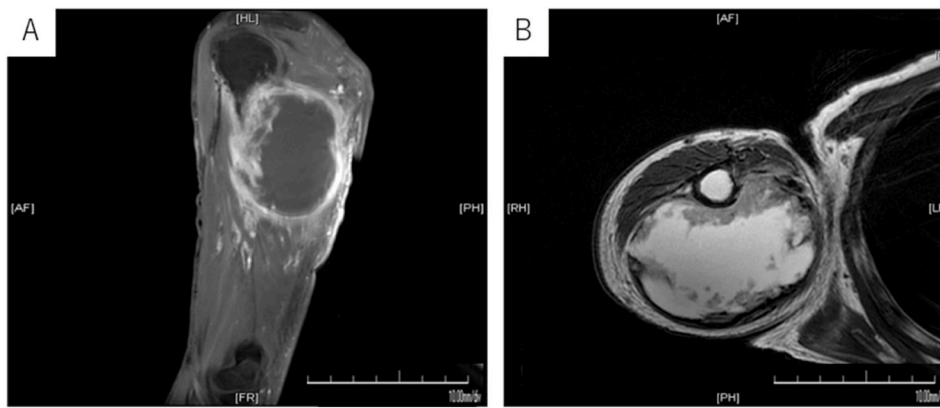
Contrast-enhanced magnetic resonance imaging/T1-weighted image (A), T2-weighted images(B) after six months of starting nab-paclitaxel.
